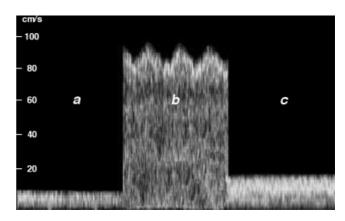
Doppler recording showing pulsation in the umbilical vein at the abdominal wall (b), but no pulsation in the cord (a) or in the intra-abdominal section (c), at 25 weeks of gestation, a common pattern observed during the second half of pregnancy.
